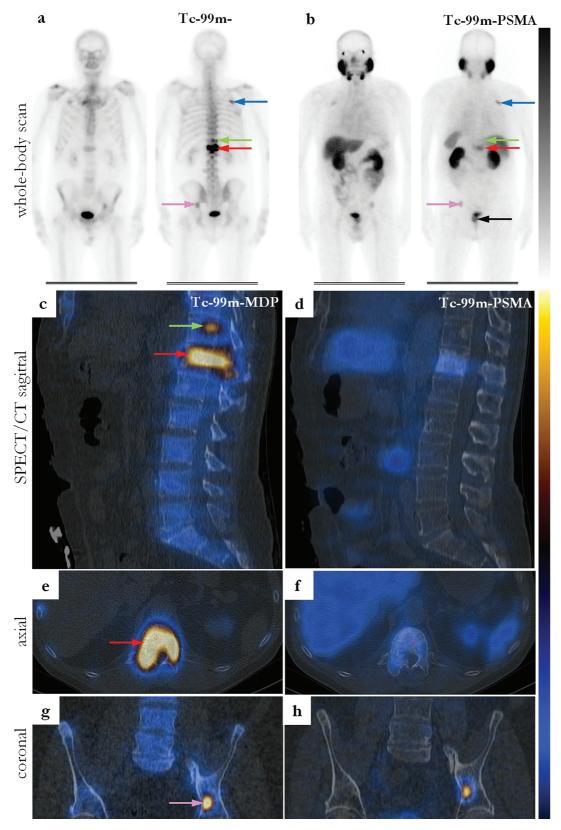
Comparison of scans with Tc-99m-methyl diphosphonate (MDP) and Tc-99m-prostate-specific membrane antigen (PSMA) after external beam radiotherapy of thoracic vertebrae 10 to 12. Within the third month after external beam radiotherapy, whole-body scans with (A) Tc-99m-MDP and (B) Tc-99m-prostate-specific membrane antigen (PSMA) revealed concordant metastatic sites in the (A, B) third rib (blue arrow) and iliac body (pink arrow). Within the radiation field, bone scan (C) was strongly positive, whereas PSMA scan (D) presented in none (T11, green arrow) to slightly (T12, red arrow) increased uptake. MDP uptake extends to the whole T12, (E) whereas PSMA uptake spares the left arcus vertebrae (F). Nonirradiated metastasis of iliac body (G, H) served as internal positive control and had uptake in both scans. SPECT/CT, single-photon emission computed tomography/computed tomography scan.
